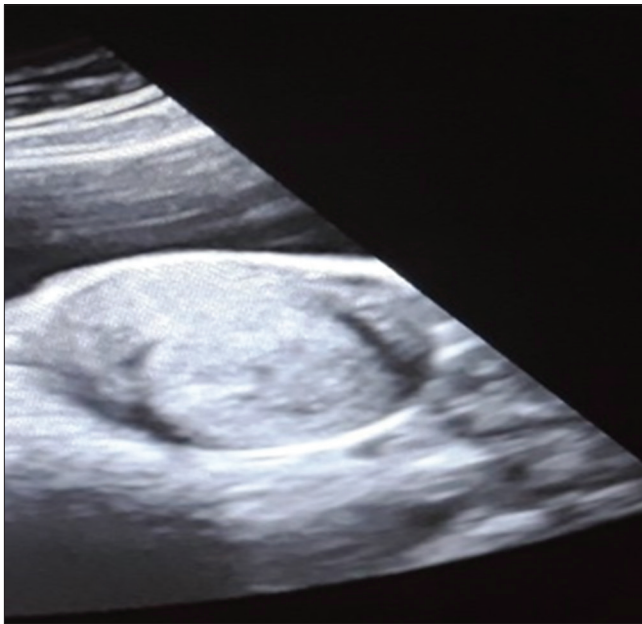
Ovarian fibrothecoma on ultrasound
